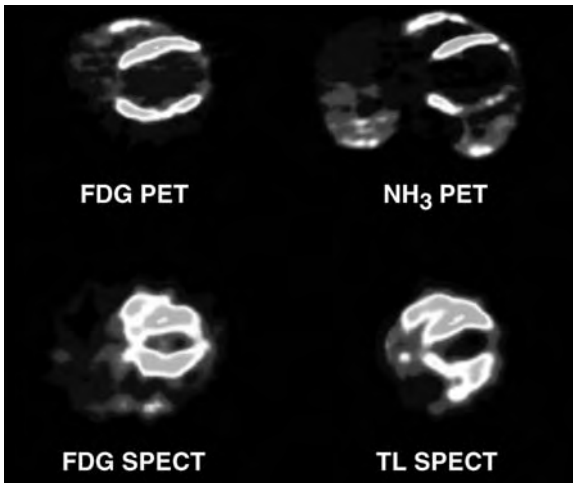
Comparison of blood flow and metabolism imaging by PET and by SPECT. For the PET study, myocardial blood flow was evaluated with ^{13}N - ammonia (NH_3), whereas for the SPECT study myocardial perfusion was assessed with ^{201}Tl (TL). (From BAX et al. 1996c)
